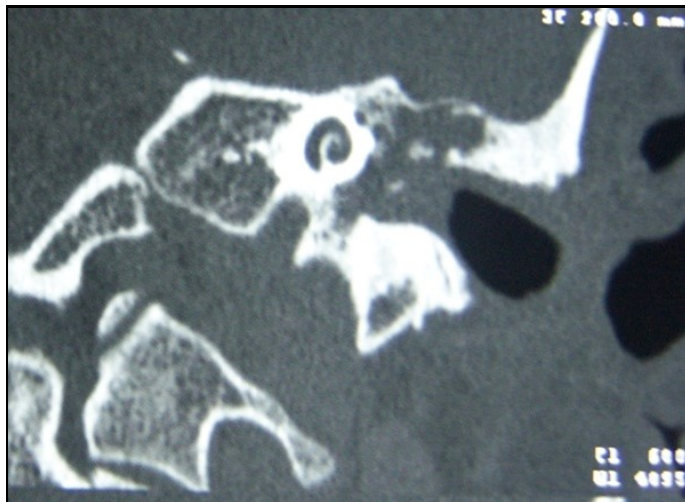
Soft tissue image causing bone erosion on temporal CT
